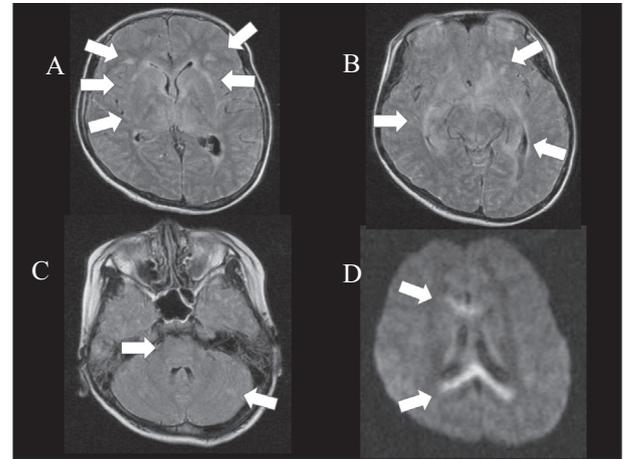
Magnetic resonance imaging (MRI) on the third hospital day in case 1. (A–C) Fluid attenuated inversion recovery (FLAIR). (D) Diffusion-weighted imaging (DWI). FLAIR showed hyperintense lesions (arrow) in the bilateral periventricular and subcortical white matter, thalamus, caudate nucleus, external capsule (A, B), midbrain (B), pons (C), and cerebellar hemisphere (C), in addition to diffuse swelling of the cerebral parenchyma, narrowing of the lateral and third ventricles, and sulcal hyperintensity because of narrowing of sulci. DWI showed hyperintense lesions (arrow) in the corpus callosum (D).
